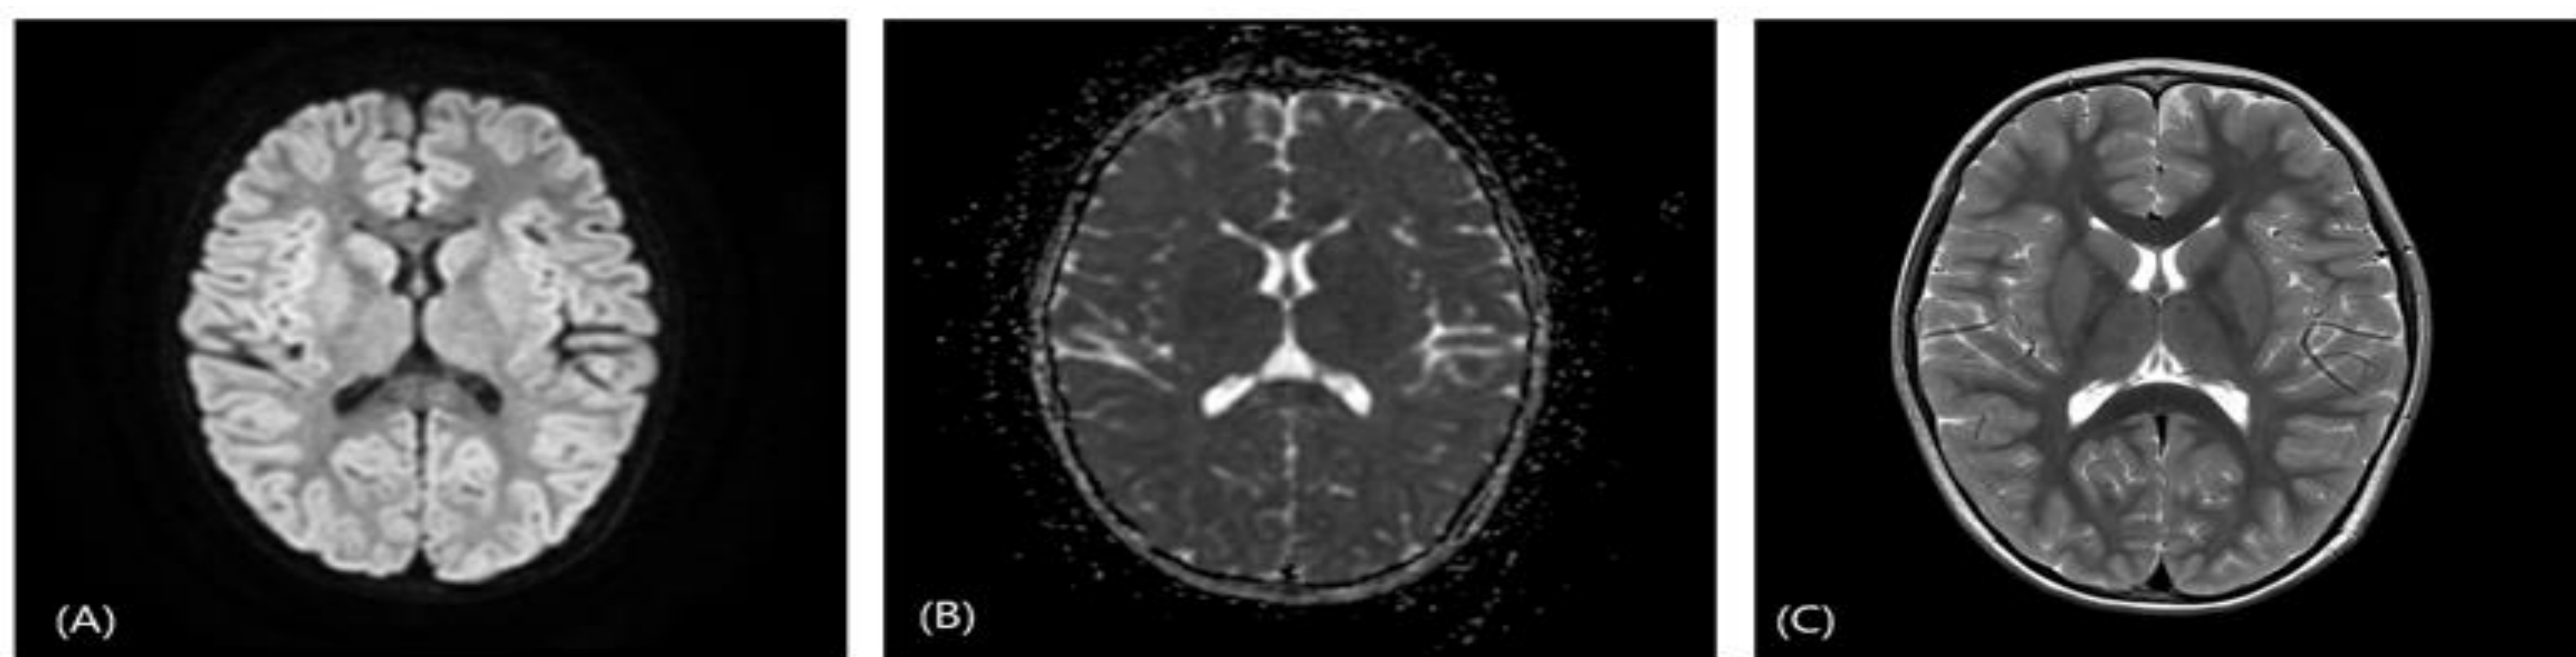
(A), (B), (C) Brain magnetic resonance image shows no abnormal findings.
